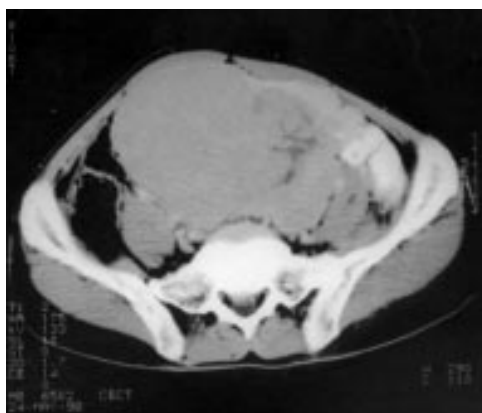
Contrast enhanced computed tomogram at the level of lower abdomen showing a bulky enhanced mass.
